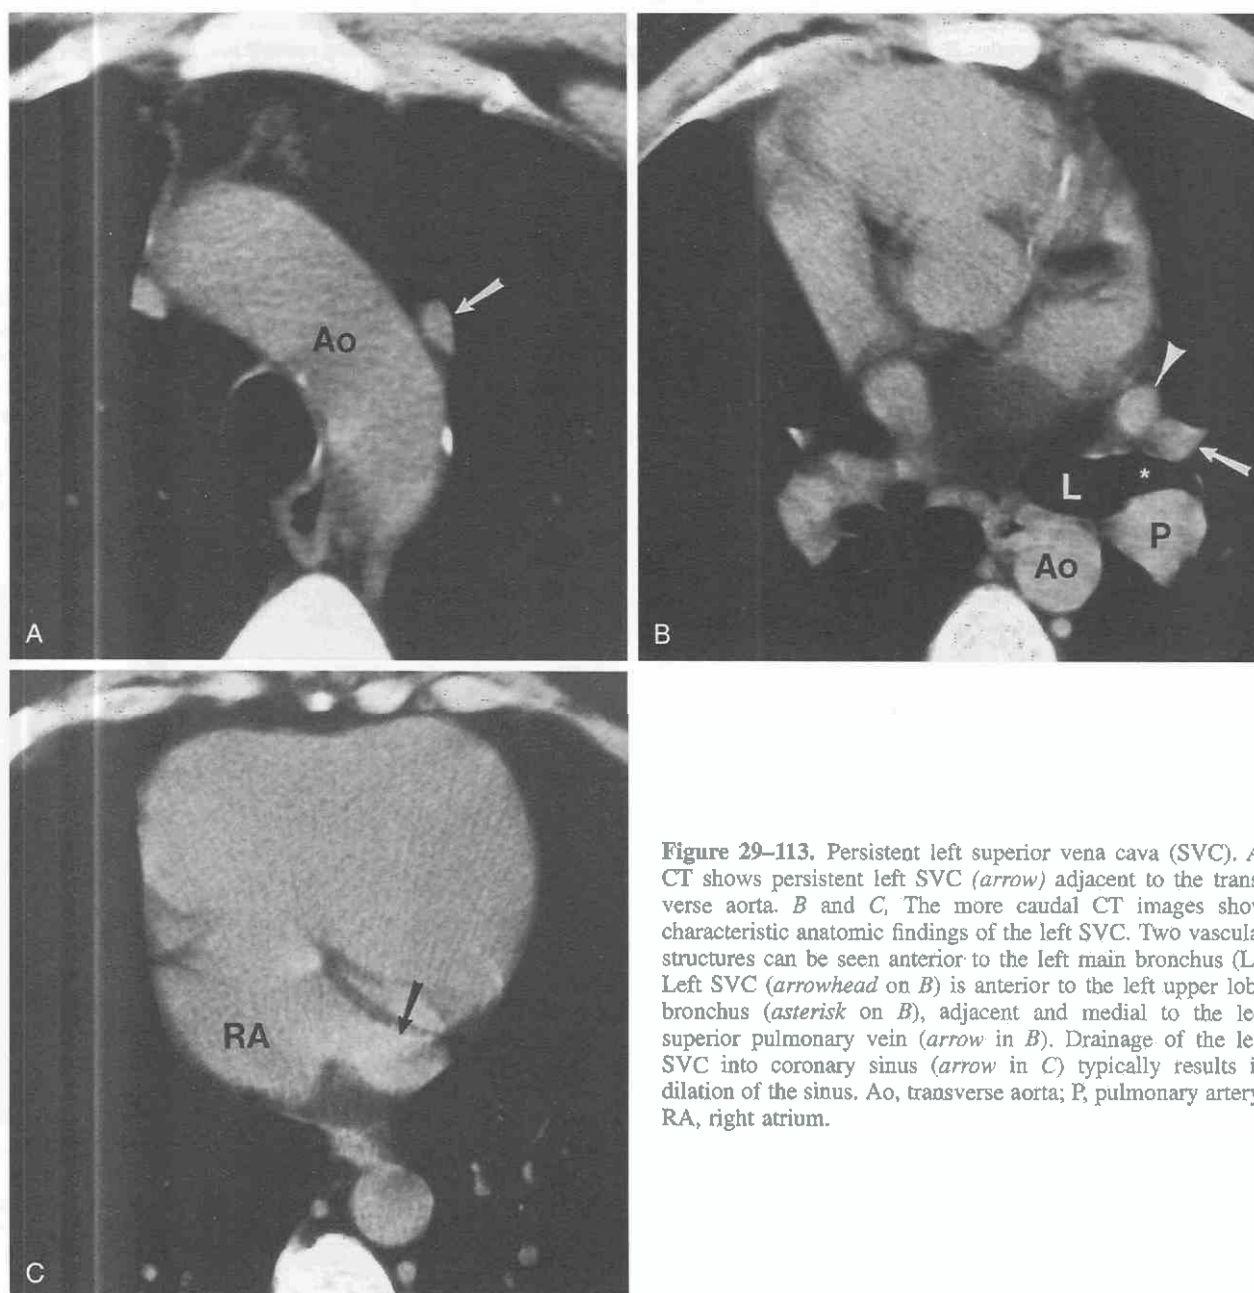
Persistent left superior vena cava (SVC). *A*, CT shows persistent left SVC (arrow) adjacent to the transverse aorta. *B* and *C*, The more caudal CT images show characteristic anatomic findings of the left SVC. Two vascular structures can be seen anterior to the left main bronchus (L). Left SVC (arrowhead on *B*) is anterior to the left upper lobe bronchus (asterisk on *B*), adjacent and medial to the left superior pulmonary vein (arrow in *B*). Drainage of the left SVC into coronary sinus (arrow in *C*) typically results in dilation of the sinus. Ao, transverse aorta; P, pulmonary artery; RA, right atrium.
